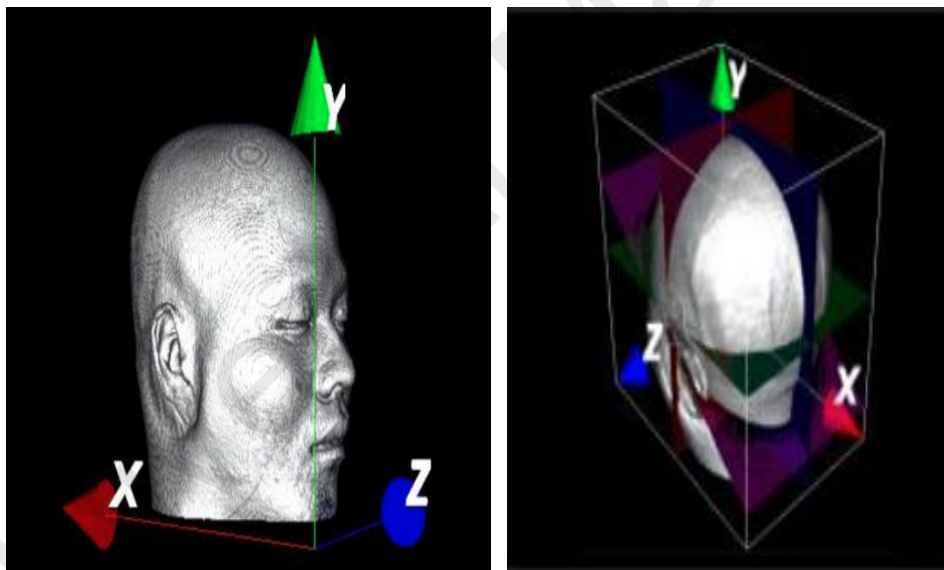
15 3D Reconstruction of MRI Head Image. use `vtkVolumeRayCastMapper` order
